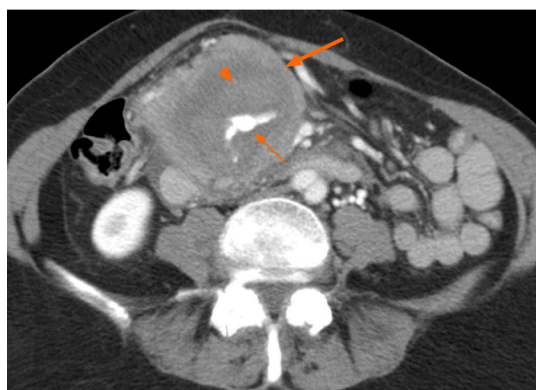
A 74-year-old female presenting with abdominal pain and nausea. Axial computed tomography shows mass (thick arrow) encircling an aneurysmal vessel (thin arrow) which is bleeding into the mass, causing hematoma (arrowhead). The tumor was biopsy-proven to be primary pancreatic lymphoma.
